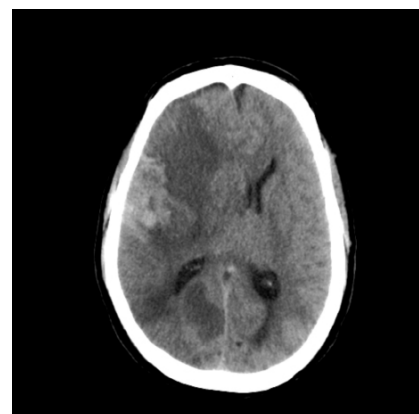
Axial noncontrast-enhanced CT head demonstrating hemorrhagic conversion of a large MCA territory infarct with right to left midline shift. CT, computed tomography; MCA, middle cerebral artery.
